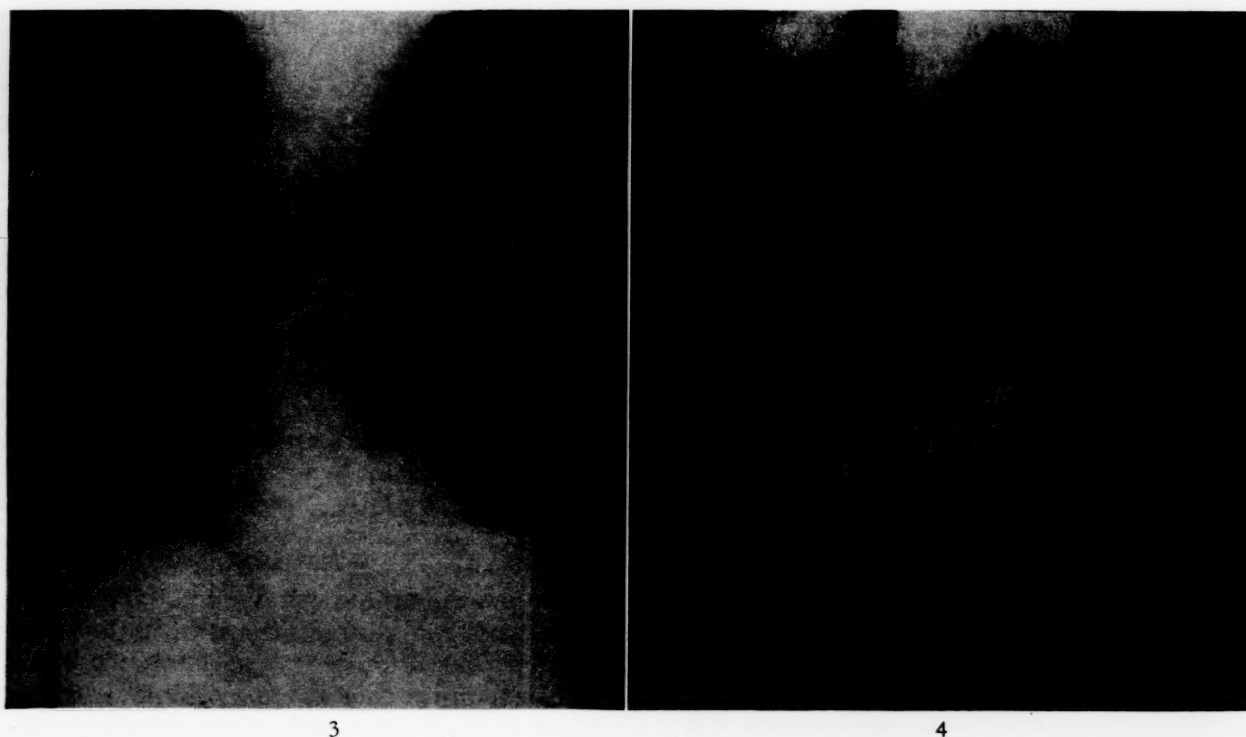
Case II. Radiograph of the chest taken the day of appearance of the emphysema showing the subcutaneous gas extending from the neck to the abdominal area, principally on the right side. There are no signs of pulmonary disruption. A faint trace of air is present in the mediastinum.
